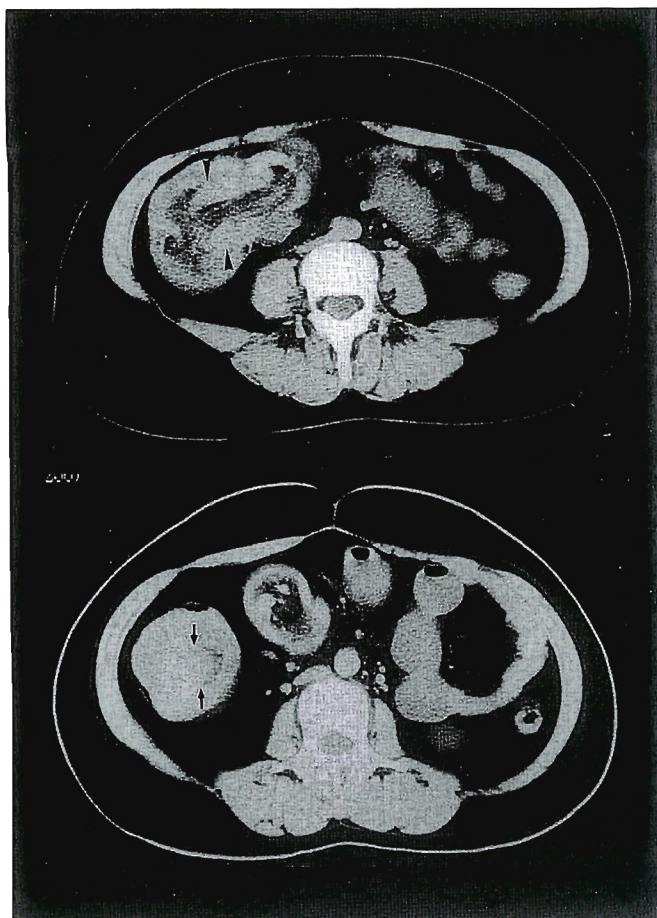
Abdominal computed tomography showing the invaginated ileal segment in the ascending colon (upper, arrow head) and the intraluminal solid mass (lower, arrow).
